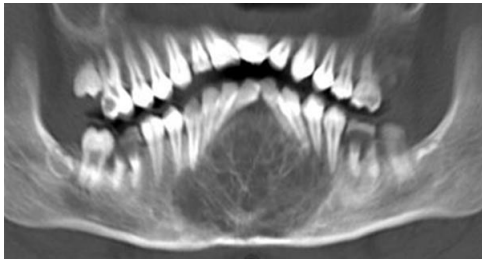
The orthopantomography of the lower jaw demonstrates the size of the tumour (50x60 mm) in the center of the mandible. Caries on 16, 26, 36 and 46.
